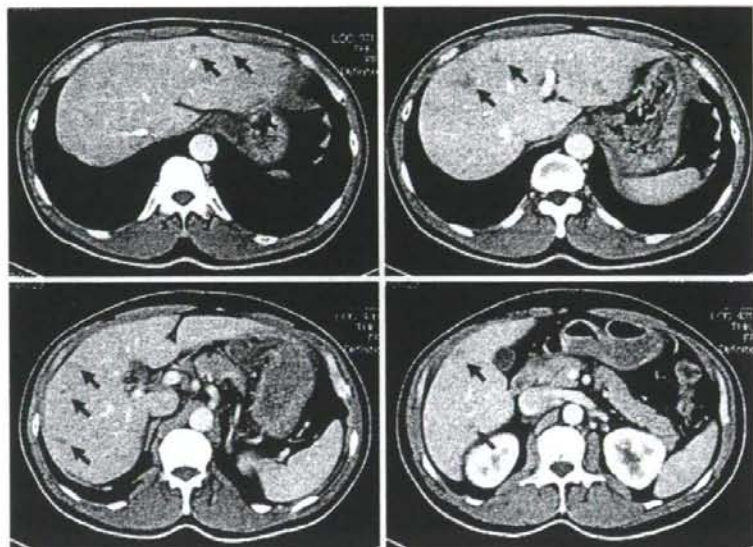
Contrast-enhanced CT scan image obtained at portal venous phase showing multiple small, ill-defined, and low-attenuation lesions in the liver of the patient (arrows).
